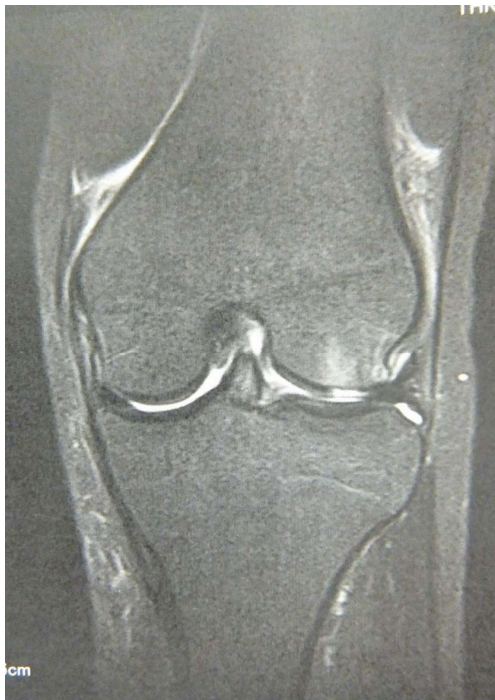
MR image of the knee of an 18-year-old female with a partially torn ACL proven on arthroscopy. This image shows a bone bruise in the middle third of the lateral femoral condyle.
